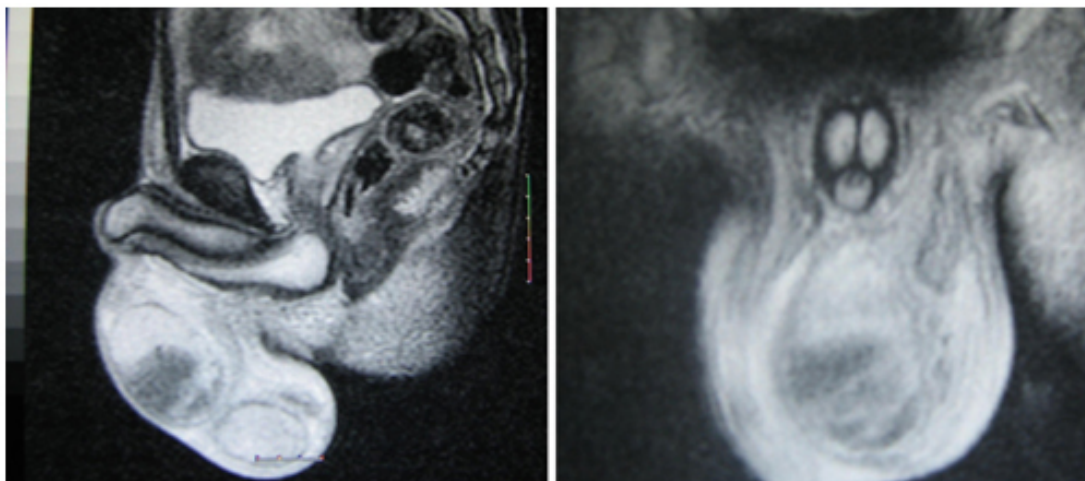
Scrotal MRI sections which was performed to rule out any testicular abscess, showed similar findings with scrotal ultrasonography.
